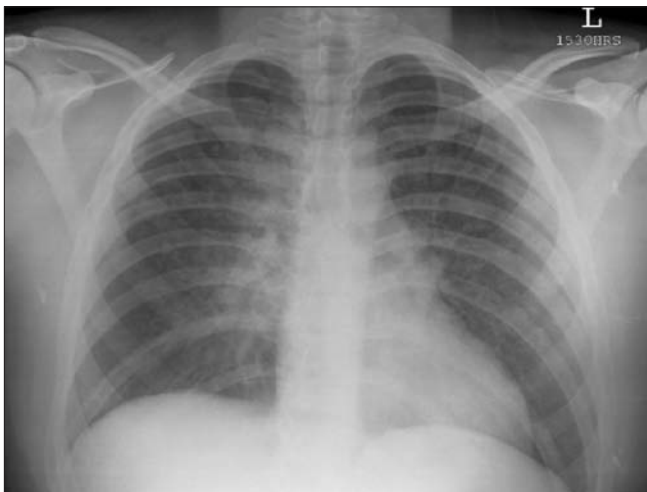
The first portable chest radiograph showing bilateral alveolar edema.
